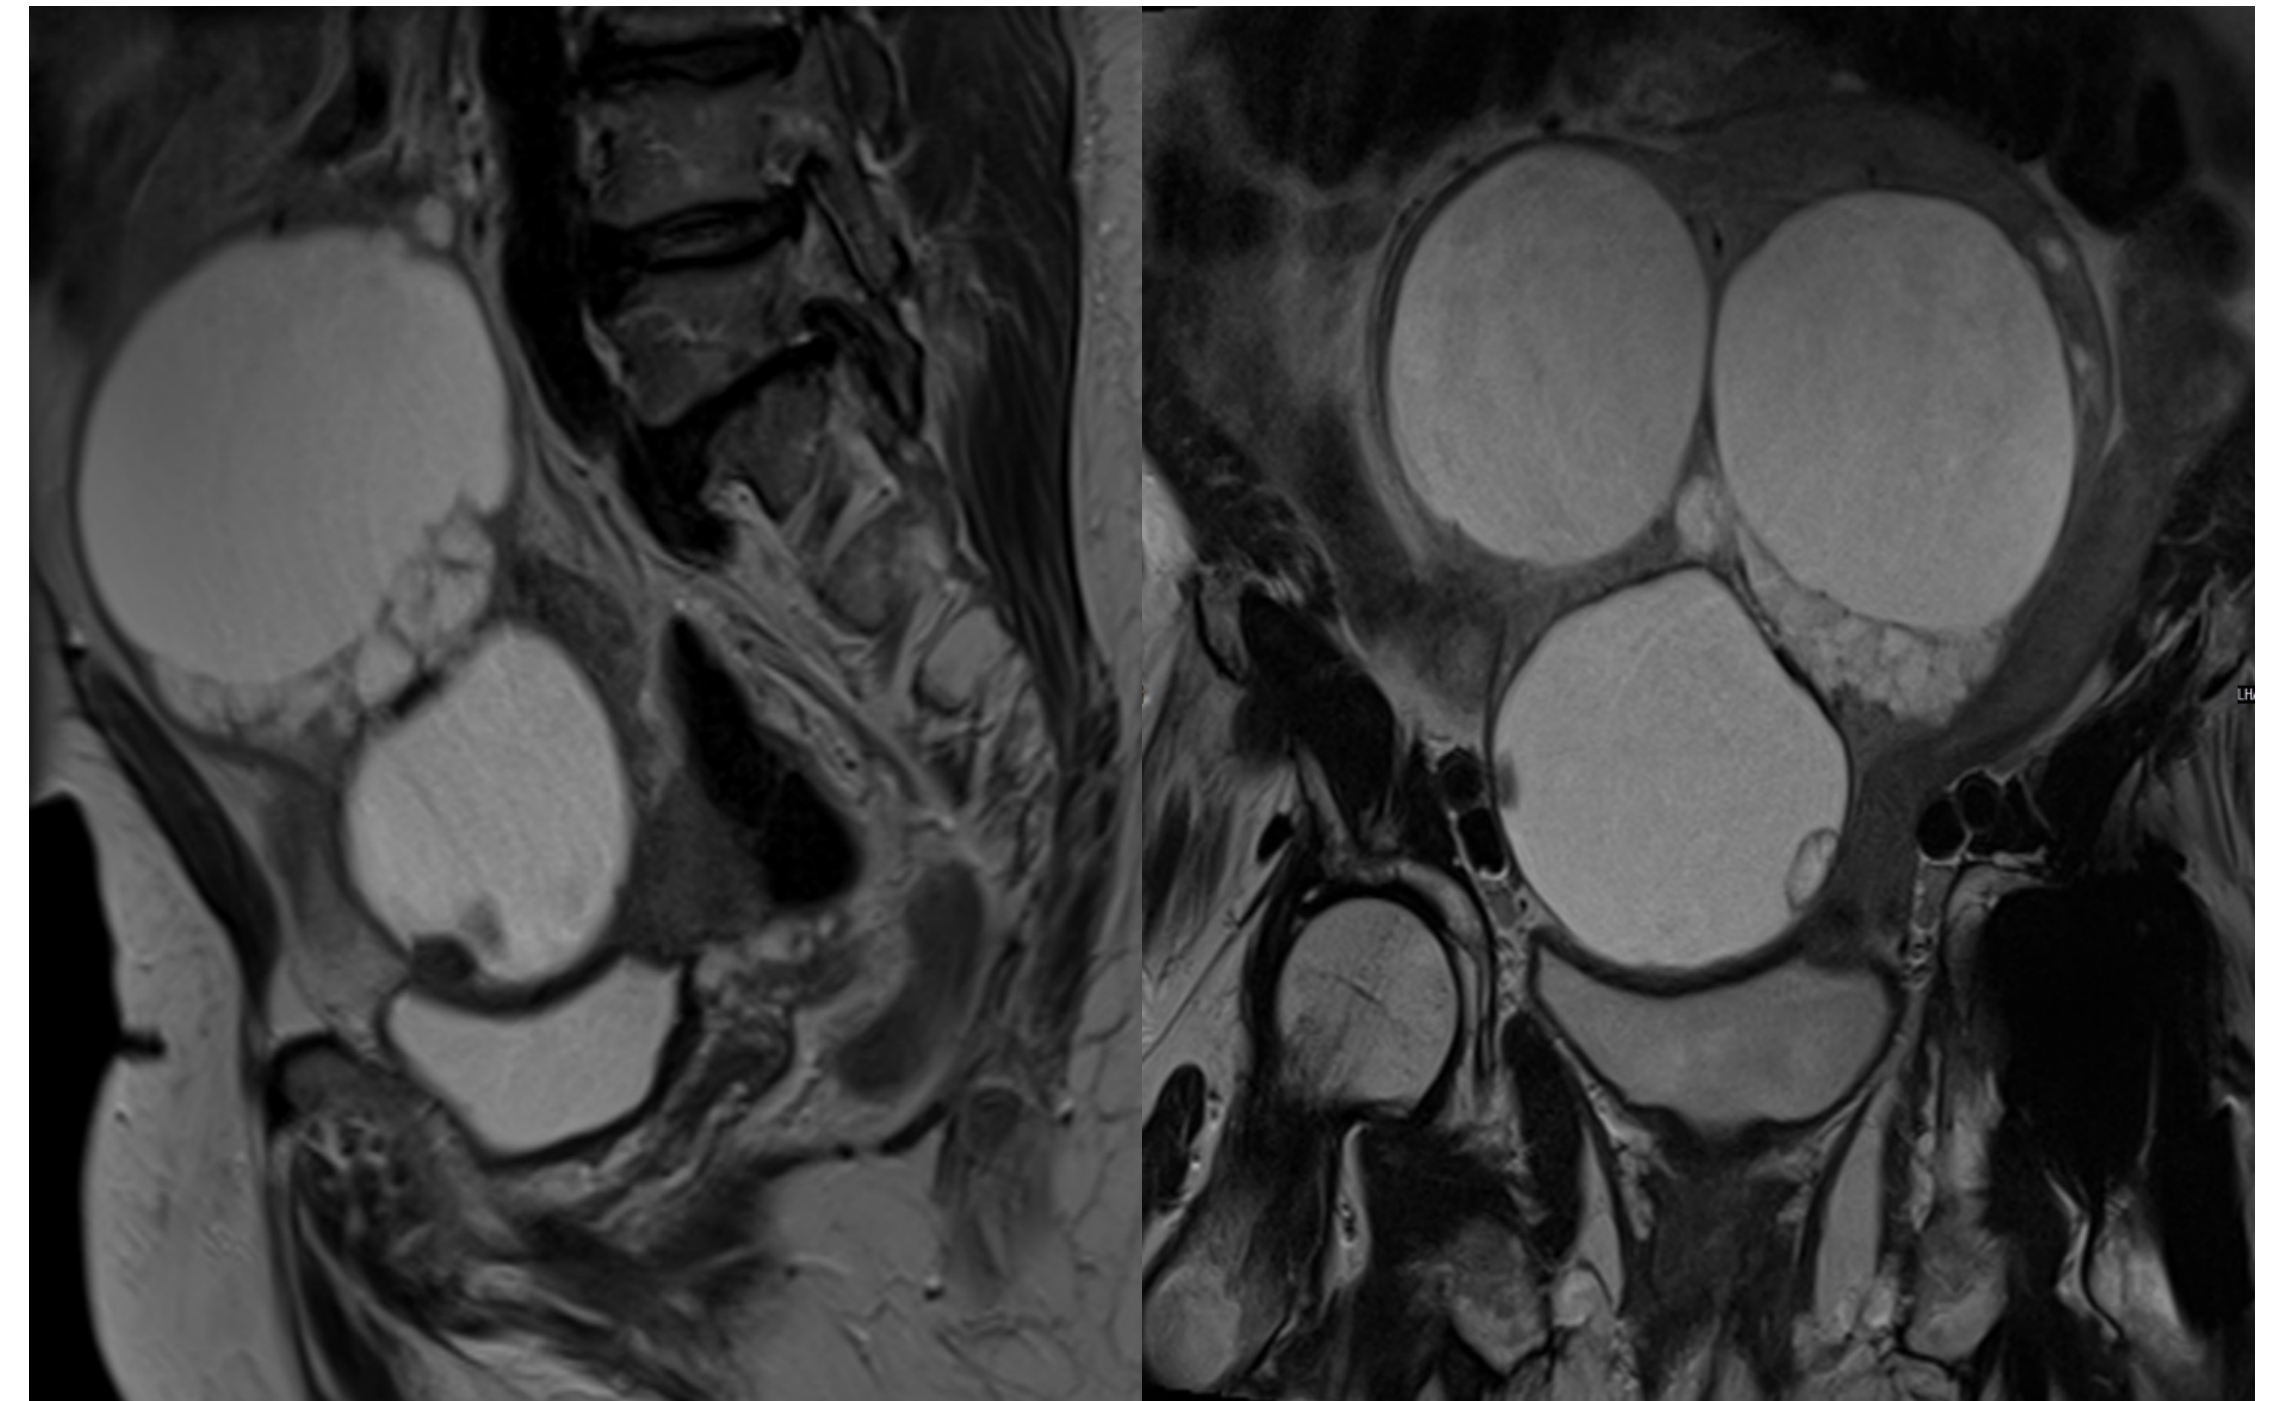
MRI Pelvis sagittal and coronal demonstrating a solid mass containing multiple cysts of varying complexity within the pelvis.
